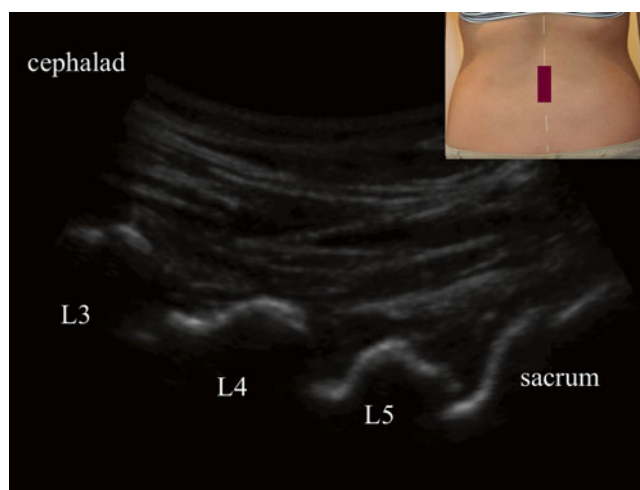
Ultrasound image of the facets from a longitudinal approach, forming a “saw tooth” pattern (Image courtesy of Andrea Trescot, MD)
